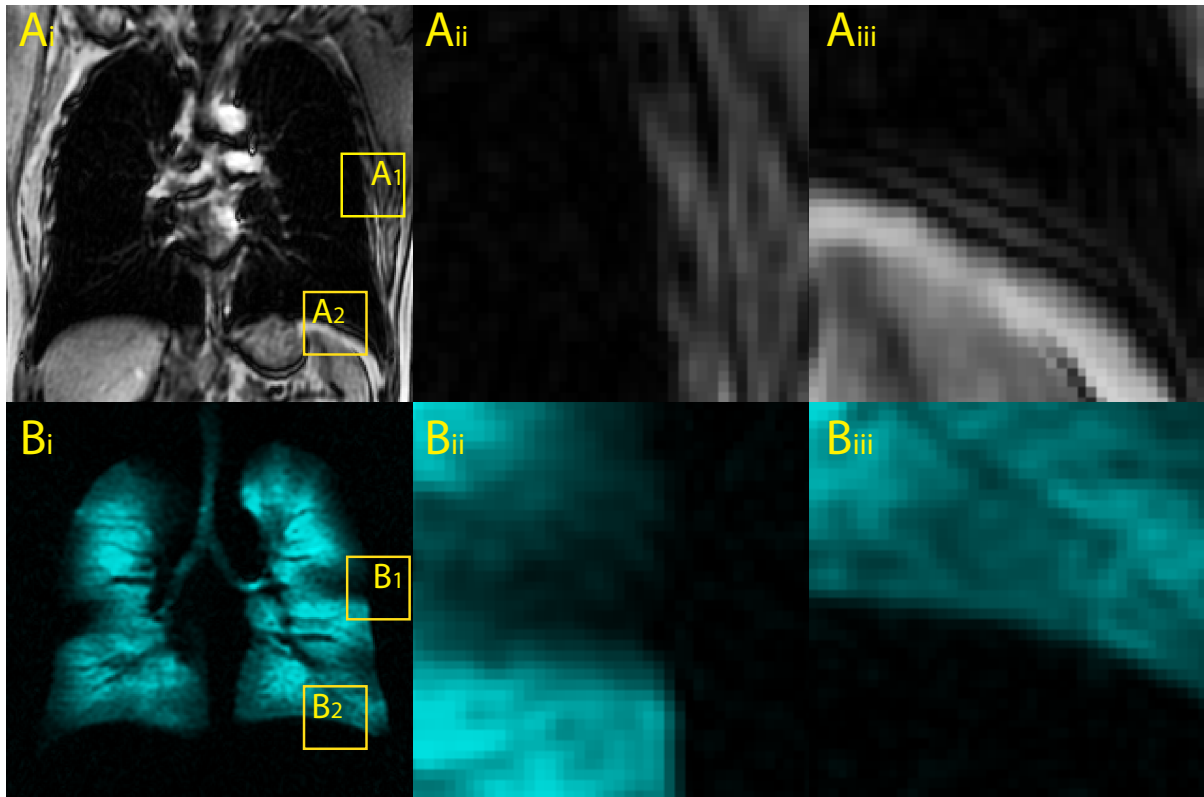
Complementary edge information in  $^1\text{H}$  and  $^3\text{He}$  MRI.  $A_i$ )  $^1\text{H}$  MRI coronal slice with inset box  $A_1$  shown expanded in  $A_{ii}$ ) and  $A_2$  shown expanded in  $A_{iii}$ ).  $B_i$ )  $^3\text{He}$  MRI coronal slice with inset box  $B_1$  shown expanded in  $B_{ii}$ ) and  $B_2$  shown expanded in  $B_{iii}$ ).
